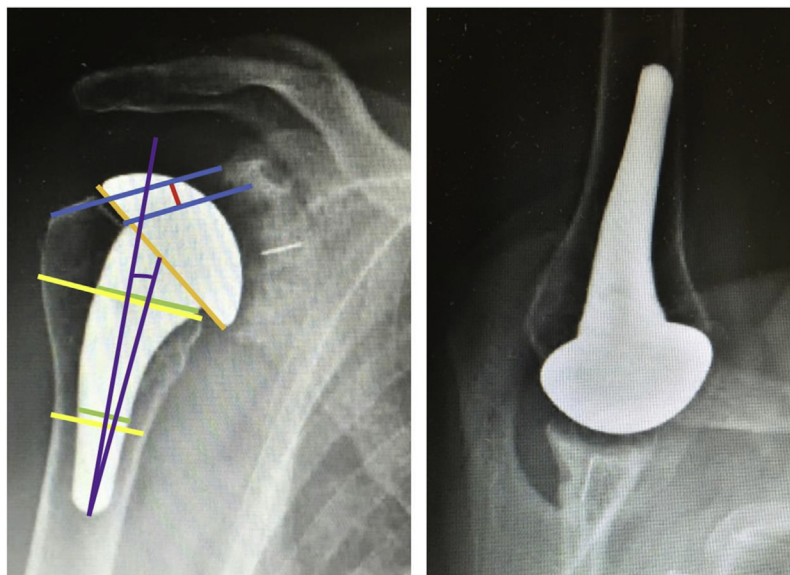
Postoperative “ideal” X-rays of TSA with some measurements. Anteroposterior and lateral X-rays of TSA with so-called ideal placement and a low-filling stem centered in the humeral shaft. The – represent the lines for measuring the height of the humeral stem: straight line drawn between the lateral edge of the greater tuberosity and the upper edge of the glenoid and parallel to this line passing through the most proximal and lateral point of the stem. The – corresponds to the distance between the 2 –: potential subsidence of the stem. – = size of the humeral head. – and – = metaphyseal and diaphyseal filling ratio. The angle alpha in violet corresponds to the angle between the line passing through the center of the humeral head and the distal end of the stem and the line representing the axis of the humeral shaft.
